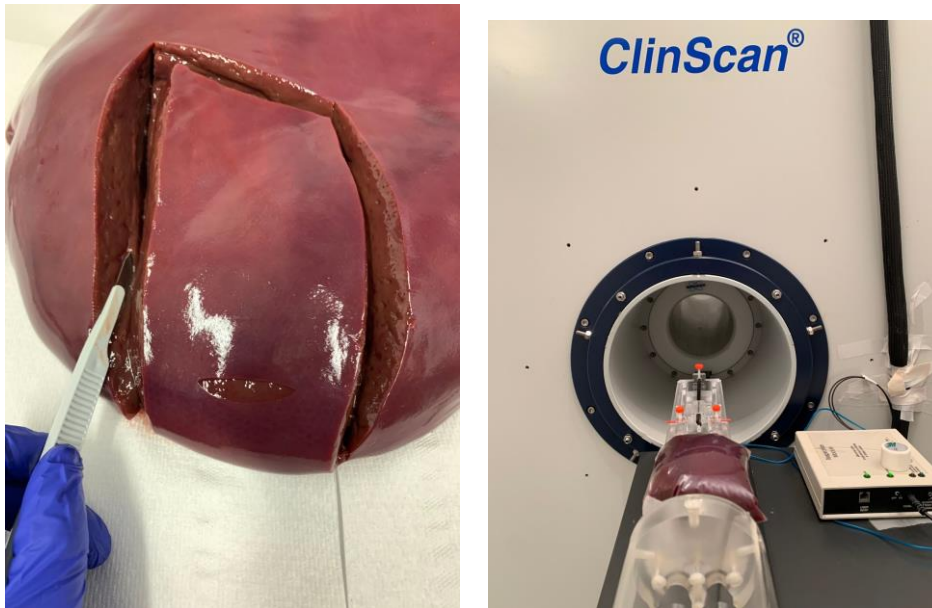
a) Initial liver excision before volumetry. b) Induction of the excised liver into the MRI.
